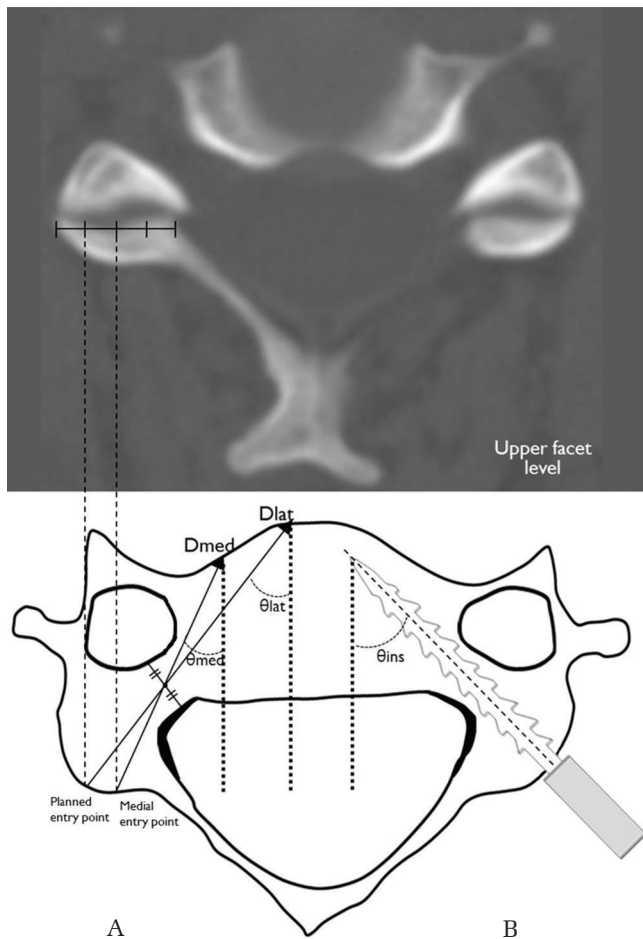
(A) A line, D_{lat} , connected the planned entry point and the axial middle point of the pedicle, shown by preoperative axial CT imaging. θ_{lat} angle between D_{lat} and a vertical line to the ground. A line and D_{med} connect a new medial entry point and the axial middle point of the pedicle. θ_{med} , angle between D_{med} and a vertical line to the ground. (B) θ_{ins} , medial angle of the actually inserted CPS as assessed by postoperative CT imaging.
